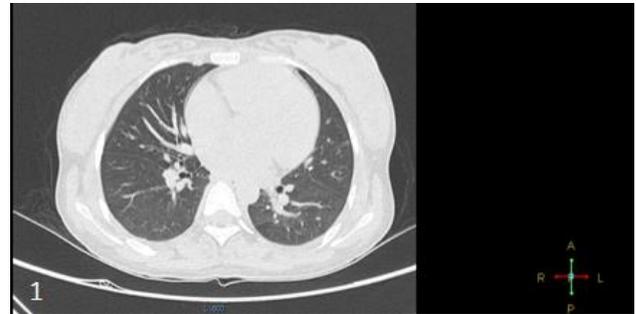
HRCT image of fibrosis of lungs (CT scoring <25%).
